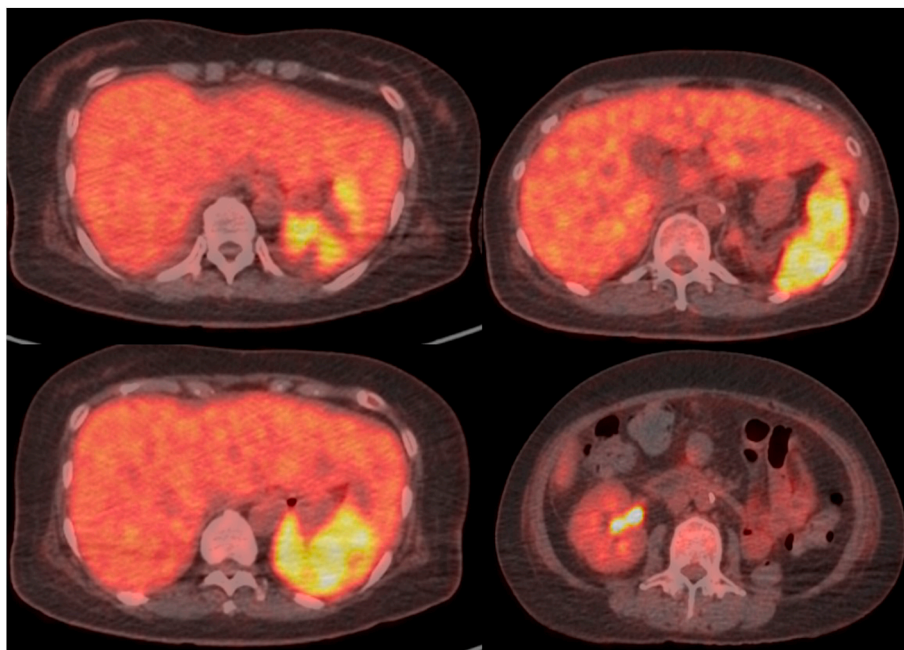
Positron emission tomography (PET) scan reveals enhanced FDG uptake in spleen and liver, indicating hemophagocytic activity and disseminated BCG-induced TB infection.
